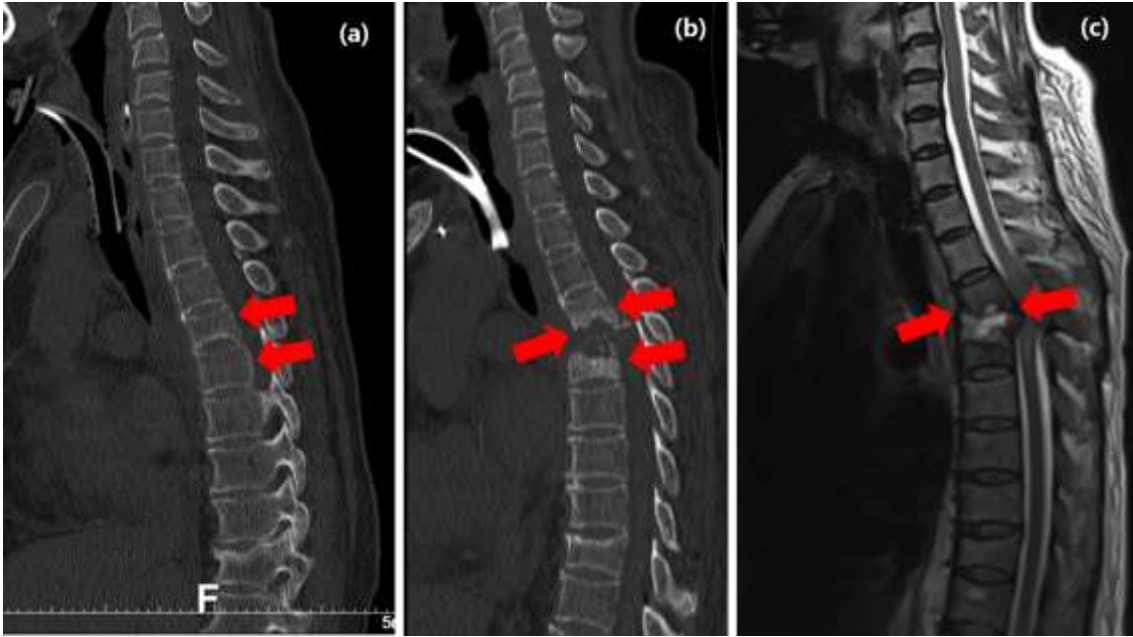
(a) Initial spine CT (b) Spine CT after 3 months (c) Spine MR after 3 months
